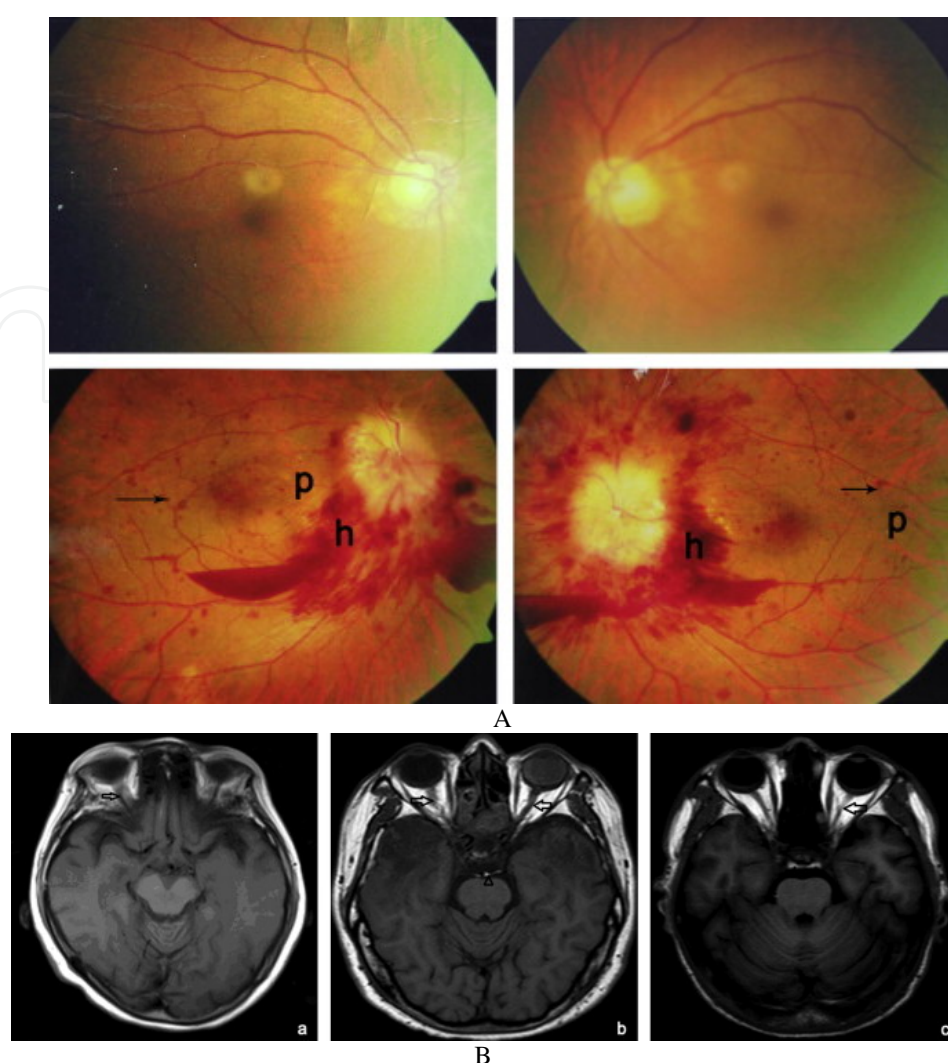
A. Fundus examination in radiation-induced optic neuropathy: ocular fundus showing flame-shaped and dot hemorrhage (bottom row, h, arrow) and cotton-wool spots (top row, bottom row, p). B. Axial MRI of three patients showing: (a, b) tortuous optic nerve with blurring of edges, and (b) optic nerve atrophy; (b, c) T1-weighted enhanced MRI showing enhancement of the optic nerves and optic chiasm.
